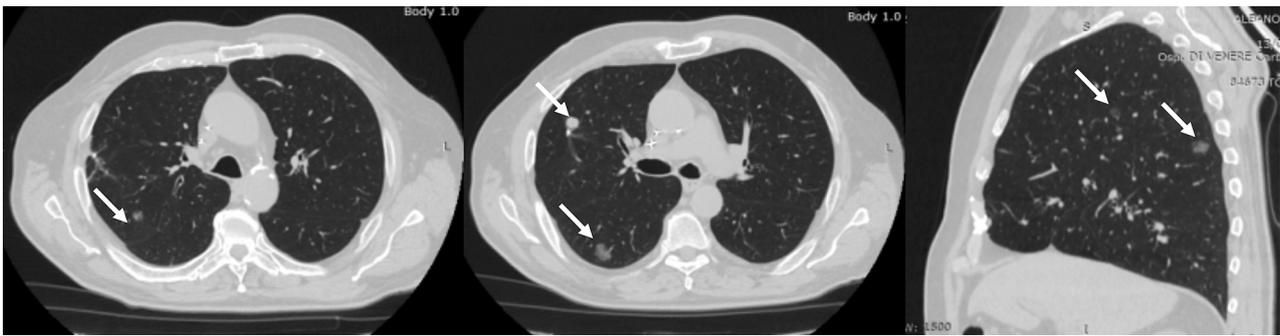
Chest computed tomographic images revealing simultaneous lung nodules and ground-glass opacities (white arrows) in the right upper and lower lobes.
